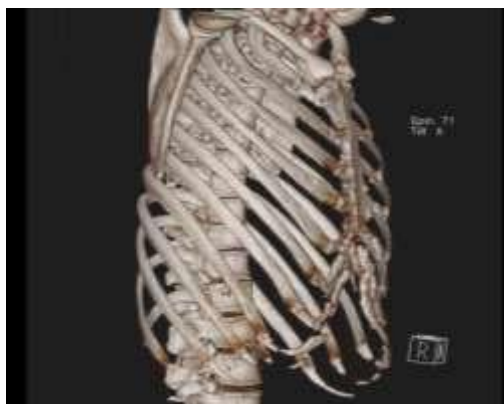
Initial chest computed tomography (CT) scan at two weeks showing no visible fracture line of the right posterior sixth and seventh ribs
